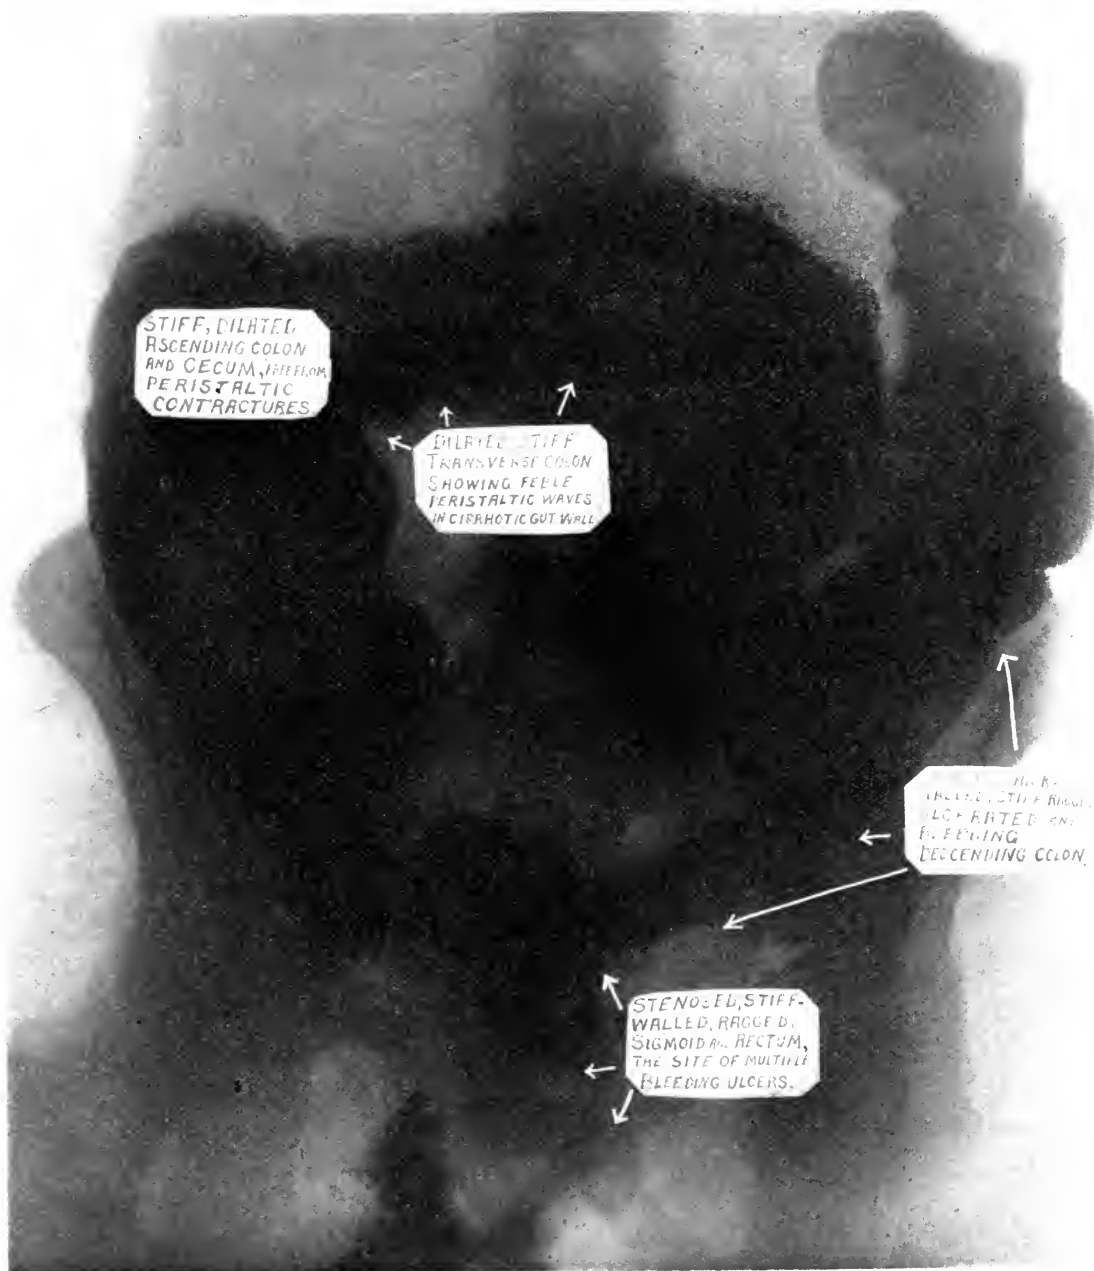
Case 2. Röntgenogram of colon, with sites of luetic lesions indicated. (Joseph Johnson, roentgenographer).
